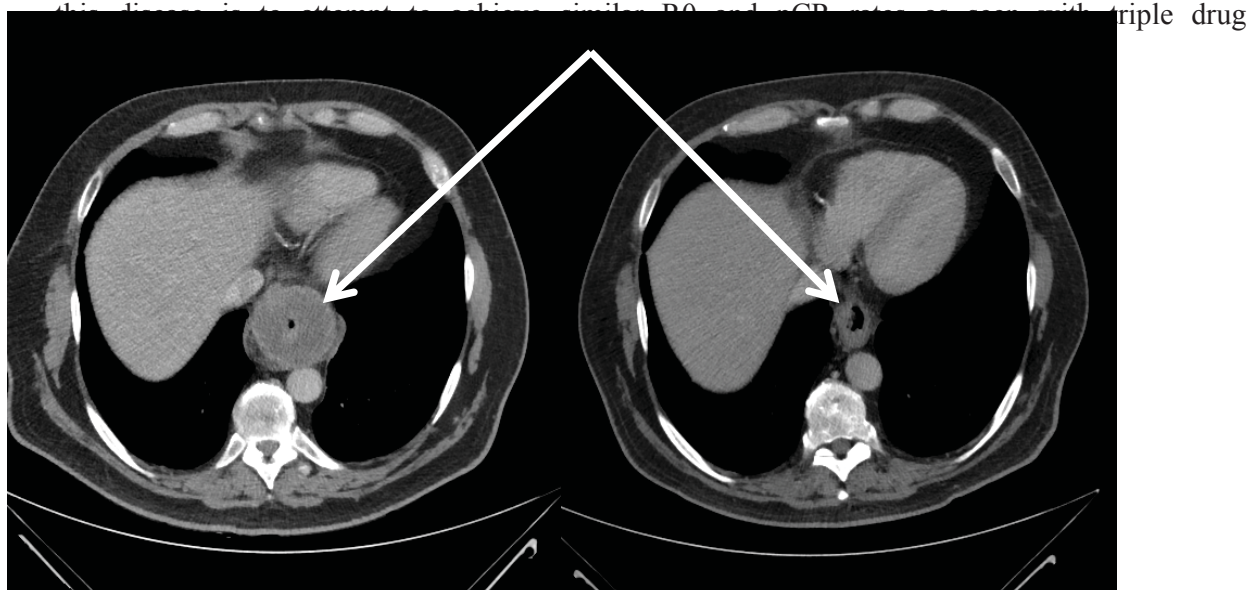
Above: CT scan and Below: PET scan; before and after mFOLFIRINOX therapy (dose reduced to 135mg/m² based on UG1A1 genotype at baseline on phase I pilot trial) in a gastroesophageal junction patient with retroperitoneal disease.
